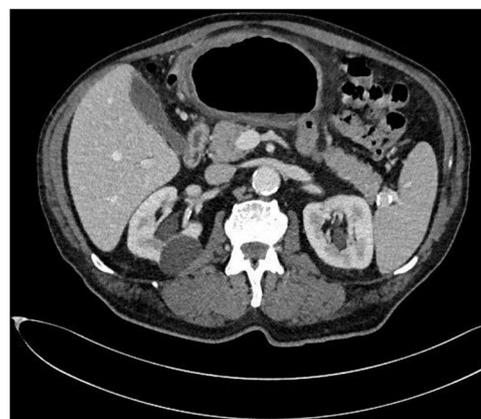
Cross-sectional CT.
